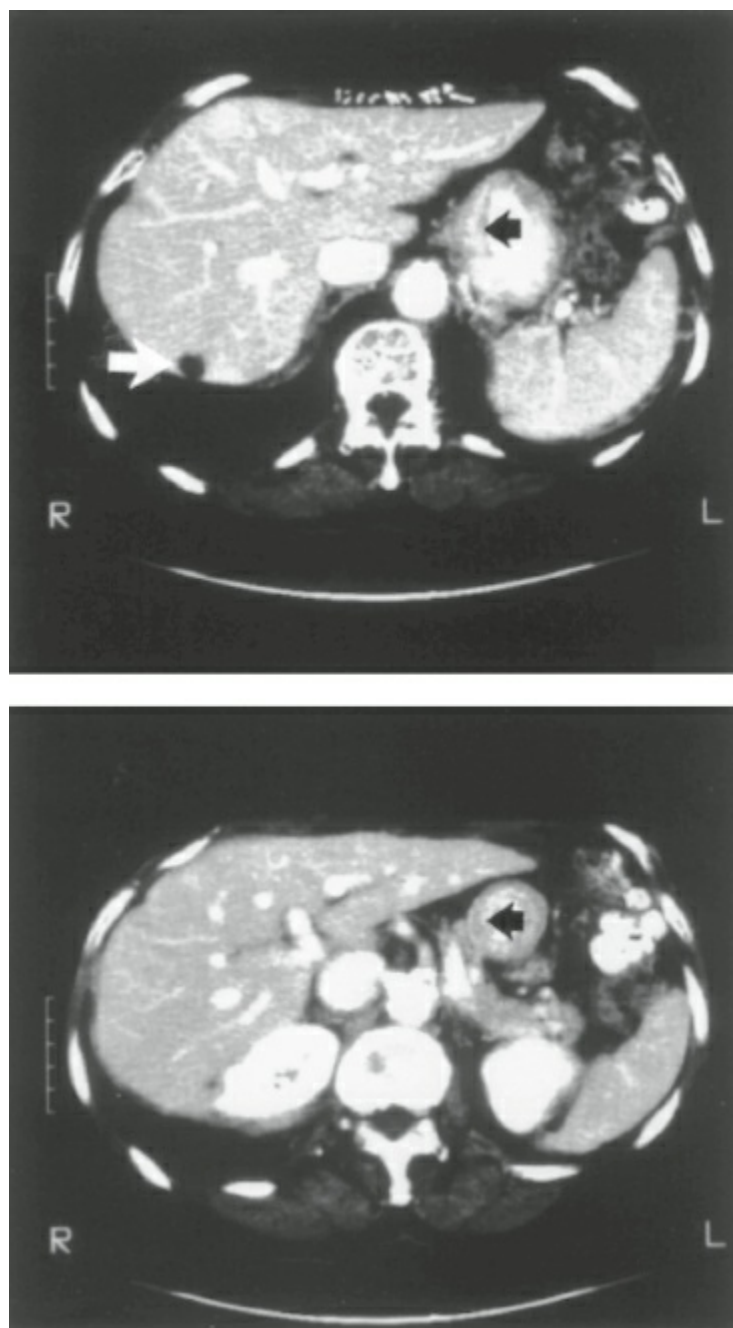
Computed tomography scans of the upper abdomen showing extensive thickening of the gastric wall (*black arrows*) caused by infiltrating adenocarcinoma and associated hepatic metastasis (*white arrow*).
